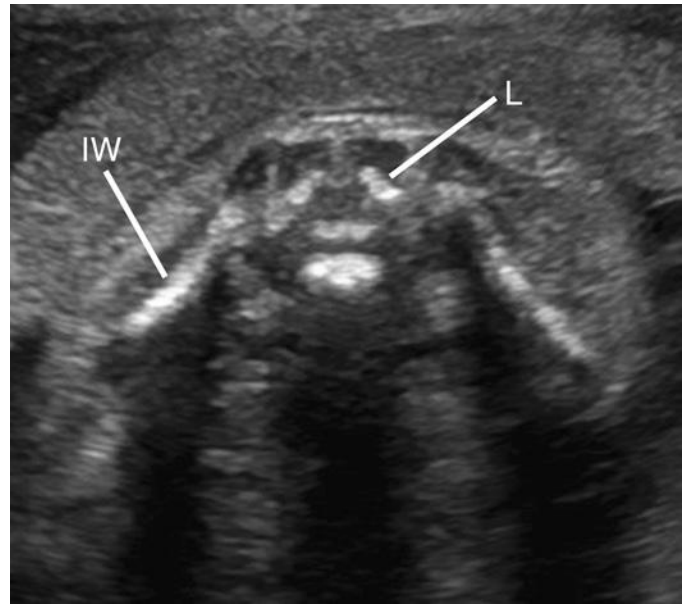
Sacral spine, transverse axial sonogram, 26 weeks. L, laminae; IW, iliac wing.
